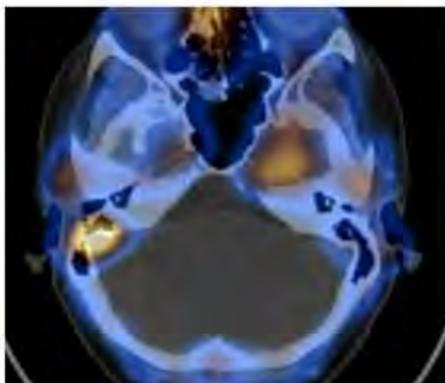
Tc99m-pertechnetate labelled RBC SPECT-CT demonstrating corresponding avid tracer activity of the left cavernous sinus.
